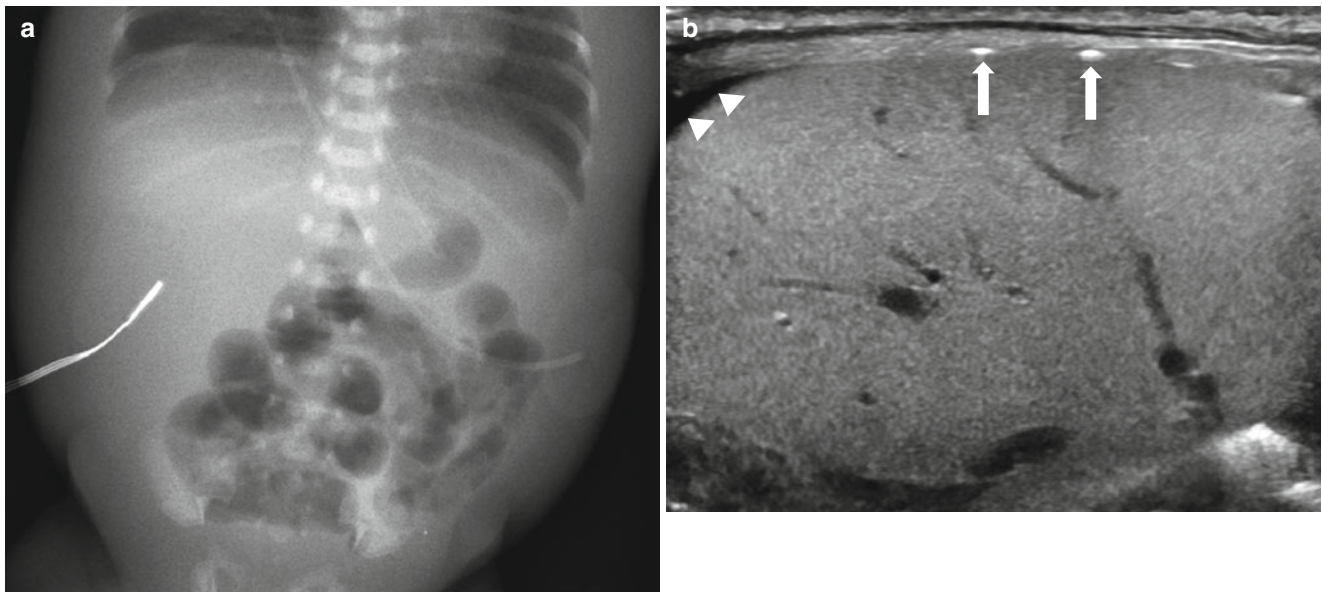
Advanced necrotizing enterocolitis. (a) Supine radiograph in a premature baby shows gaseous dilatation of the bowel loops and marked thickening of the abdominal wall, probably due to edema. Free air is not definitely noted. (b) US demonstrates multifocal
